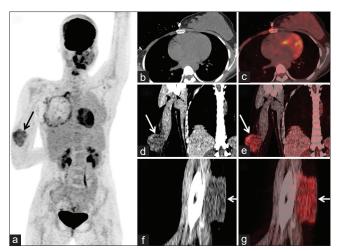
(a) Maximum intensity projection image of positron emission tomography- computed tomography scan showing a large photopenic area with a rim of radiotracer uptake in the chest region on the right side corresponding to an operated right breast on computed tomography (b) and fused positron emission tomography-computed tomography (c) images with the hot rim denoting increased tracer uptake around the surgical margins. Also noted in (a) is an enlarged area of tracer uptake in the right distal arm (d). Coronal computed tomography showing mass lesion in the posterior right arm showing increased fluorodeoxyglucose uptake on fused positron emission tomography-computed tomography image (e and f). Sagittal computed tomography showing mass lesion in the posterior right arm showing increased fluorodeoxyglucose uptake on fused positron emission tomography-computed tomography image (g)
